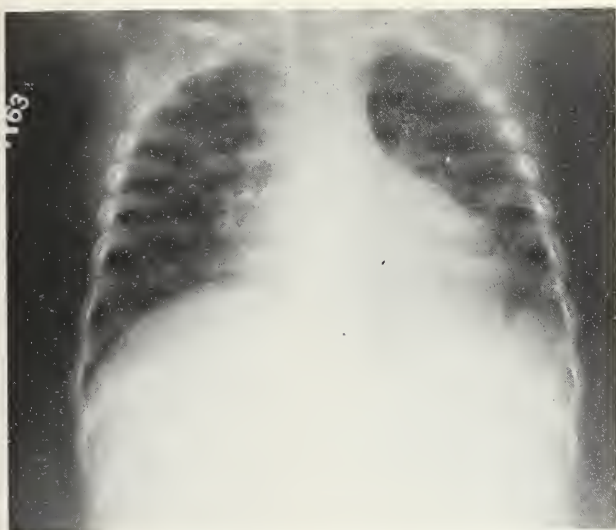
Preoperative chest X-ray (case #1) shows cardiomegaly and bilateral infiltrates.
